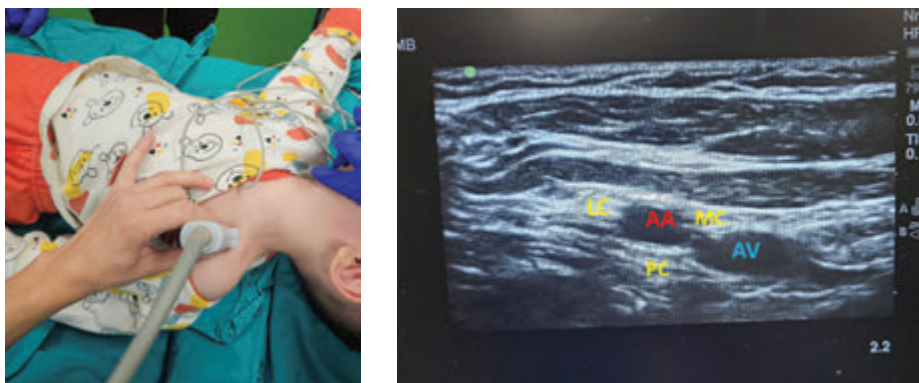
a – position of the linear probe for performing infraclavicular brachial plexus block; b – ultrasound findings of infraclavicular block in a 3-year-old child: AA – axillary artery, AV – axillary vein, LC – lateral cord, MC – medial cord and PC – posterior cord of the brachial plexus
